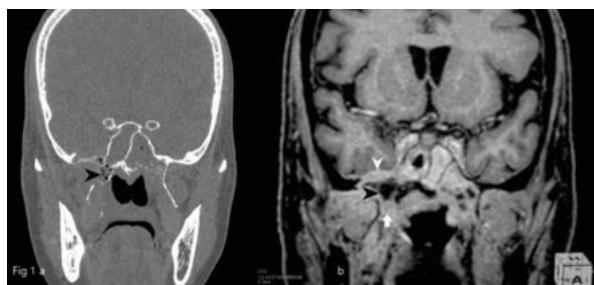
37-year-old male with mucormycosis involving sphenoid bone. CT coronal image of mottled air density foci in right greater wing of sphenoid and root of pterygoid plates (black arrowhead).
